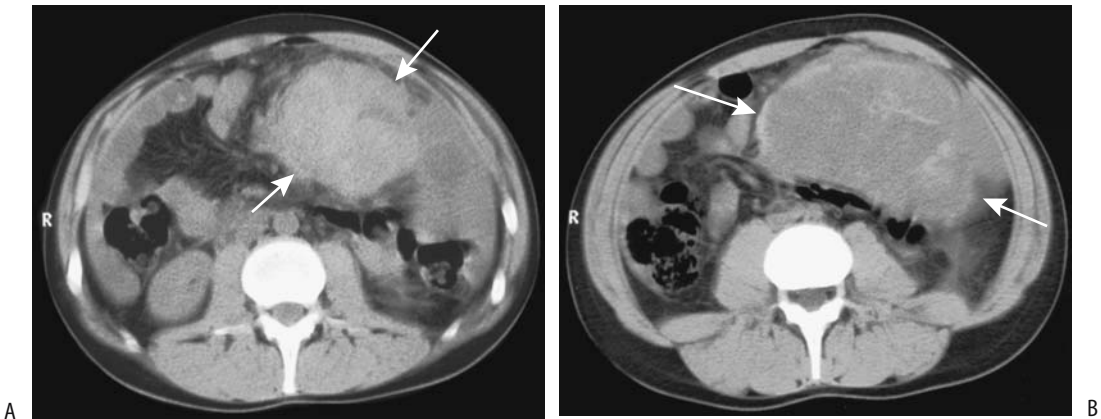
Metastatic seminoma. A,B: Two CT images identify a large, poorly marginated intraabdominal tumor (arrows). Extensive peritoneal involvement, including ascites, was also evident. (Courtesy of Algidas Basevicius, M.D., Kaunas Medical University, Kaunas, Lithuania.)
